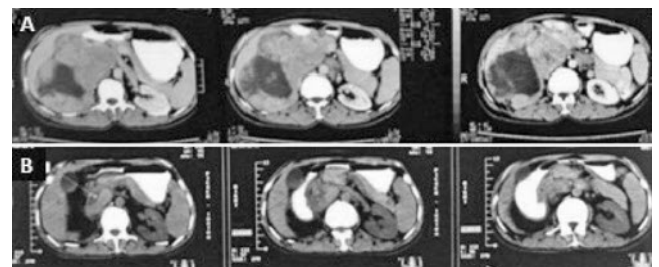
(A) Preoperative CT scan of right sided adrenocortical carcinoma at the level of LV2/3. Necrotic right adrenal mass attached to the liver and the second portion of the duodenum with displacement of the right kidney and IVC. (B) Postoperative CT scan of adrenocortical carcinoma (tumour removed)
